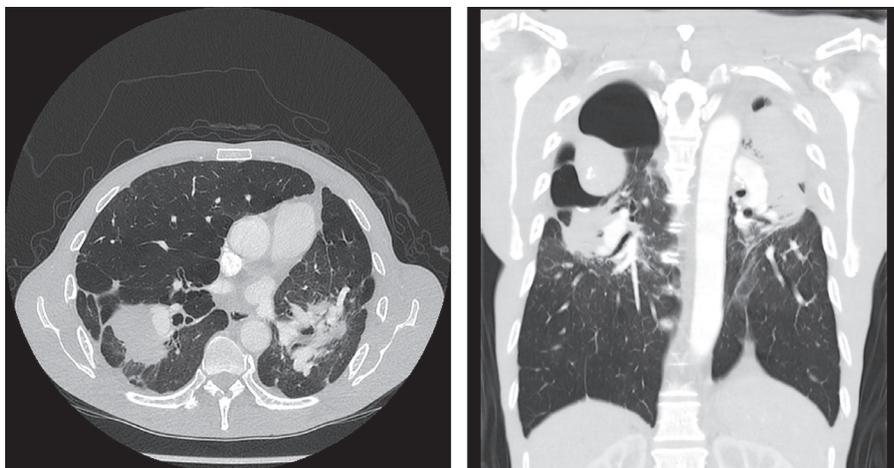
High-resolution chest computed tomography showing progressive massive fibrotic silicosis complicated by pneumothorax.
